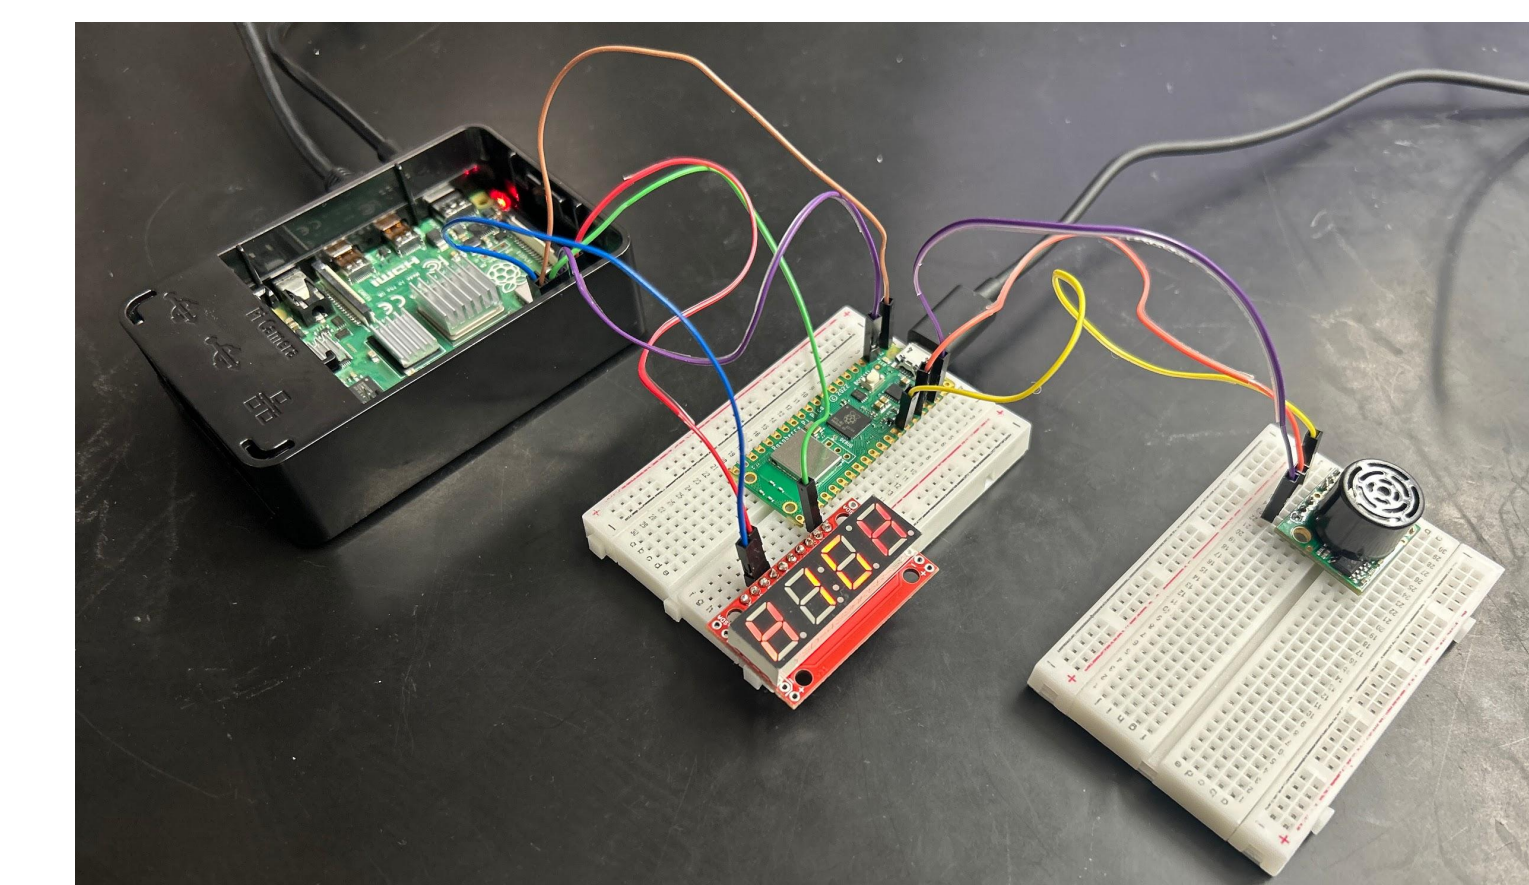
Functional wired version, includes digital display, Raspberry Pi 4, and ultrasonic sensor
